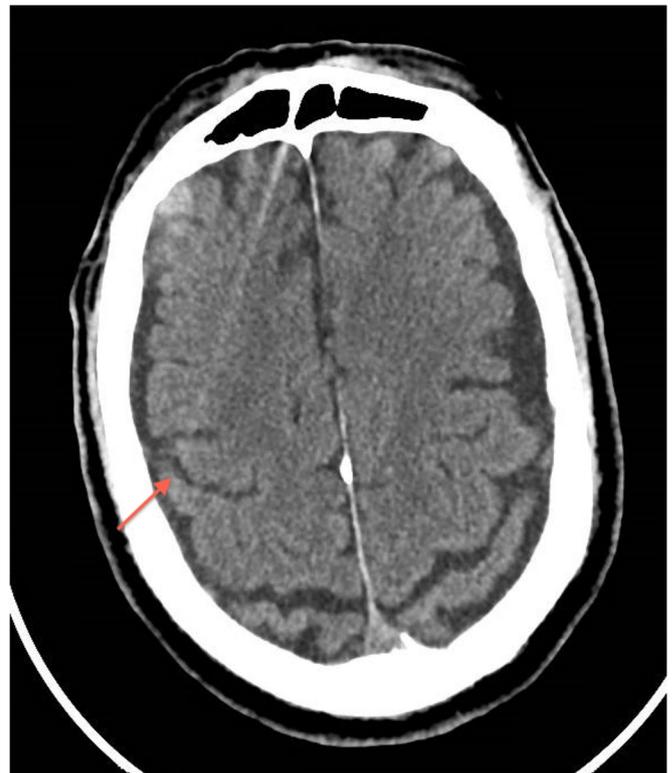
CT Brain with age indeterminate findings.
